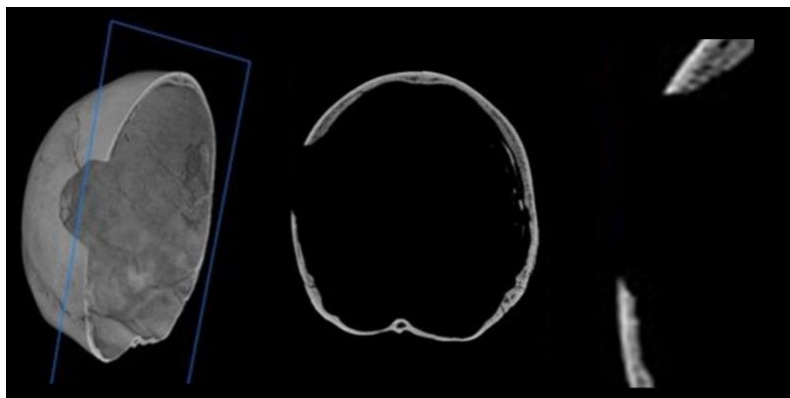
CT imaging of the cone crack in Case 2, including cutaway/slice view showing internal beveling (right)
